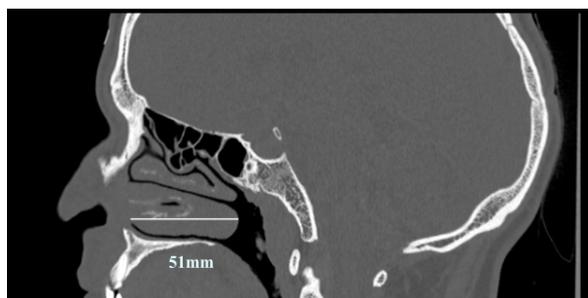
Sagittal computed tomography section showing measurement of the length of hypertrophied left inferior turbinate
